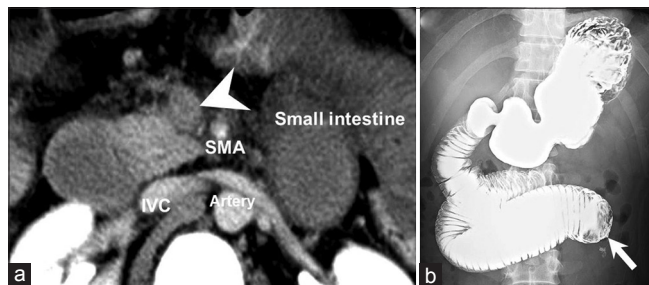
(a) Computed tomography with contrast enhancement of the abdomen reveals superior mesenteric vein thrombosis (white arrow head) adjacent to the superior mesenteric artery. (b) Upper gastrointestinal barium study reveals marked obstruction over the junction between the duodenum and jejunum (white arrow)
